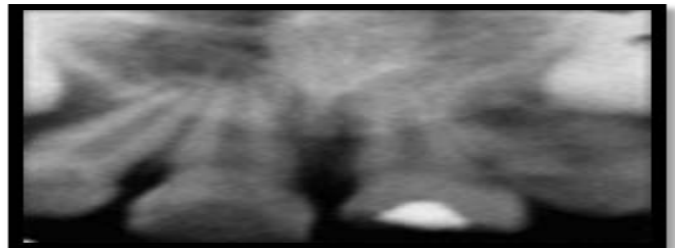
Periapical radiograph showing placement of CaOH dressing
